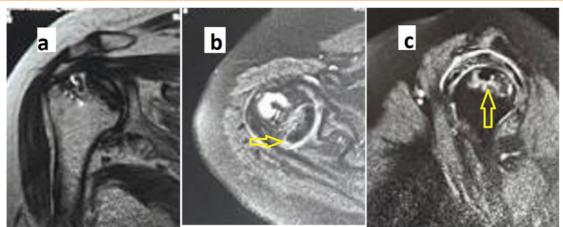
Follow-up MRI(1 year): Well-healed rotator cuff repair(a) with sclerotic AVN lesion marginally reduced size with areas of lucency around lesion suggesting revascularization (yellow arrow)(b) &(c)
